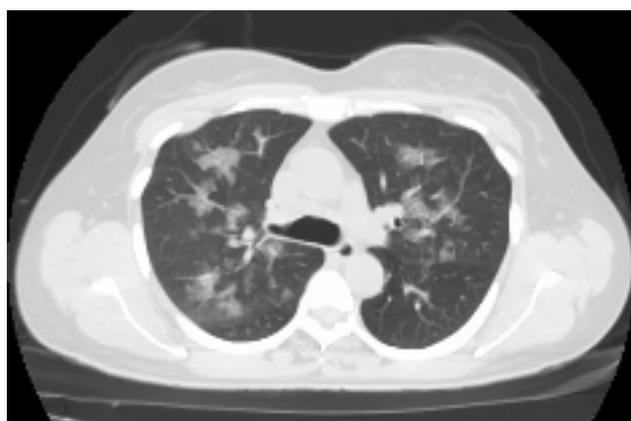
Thorax computed tomography showing bilateral infiltration consistent with aspiration.
